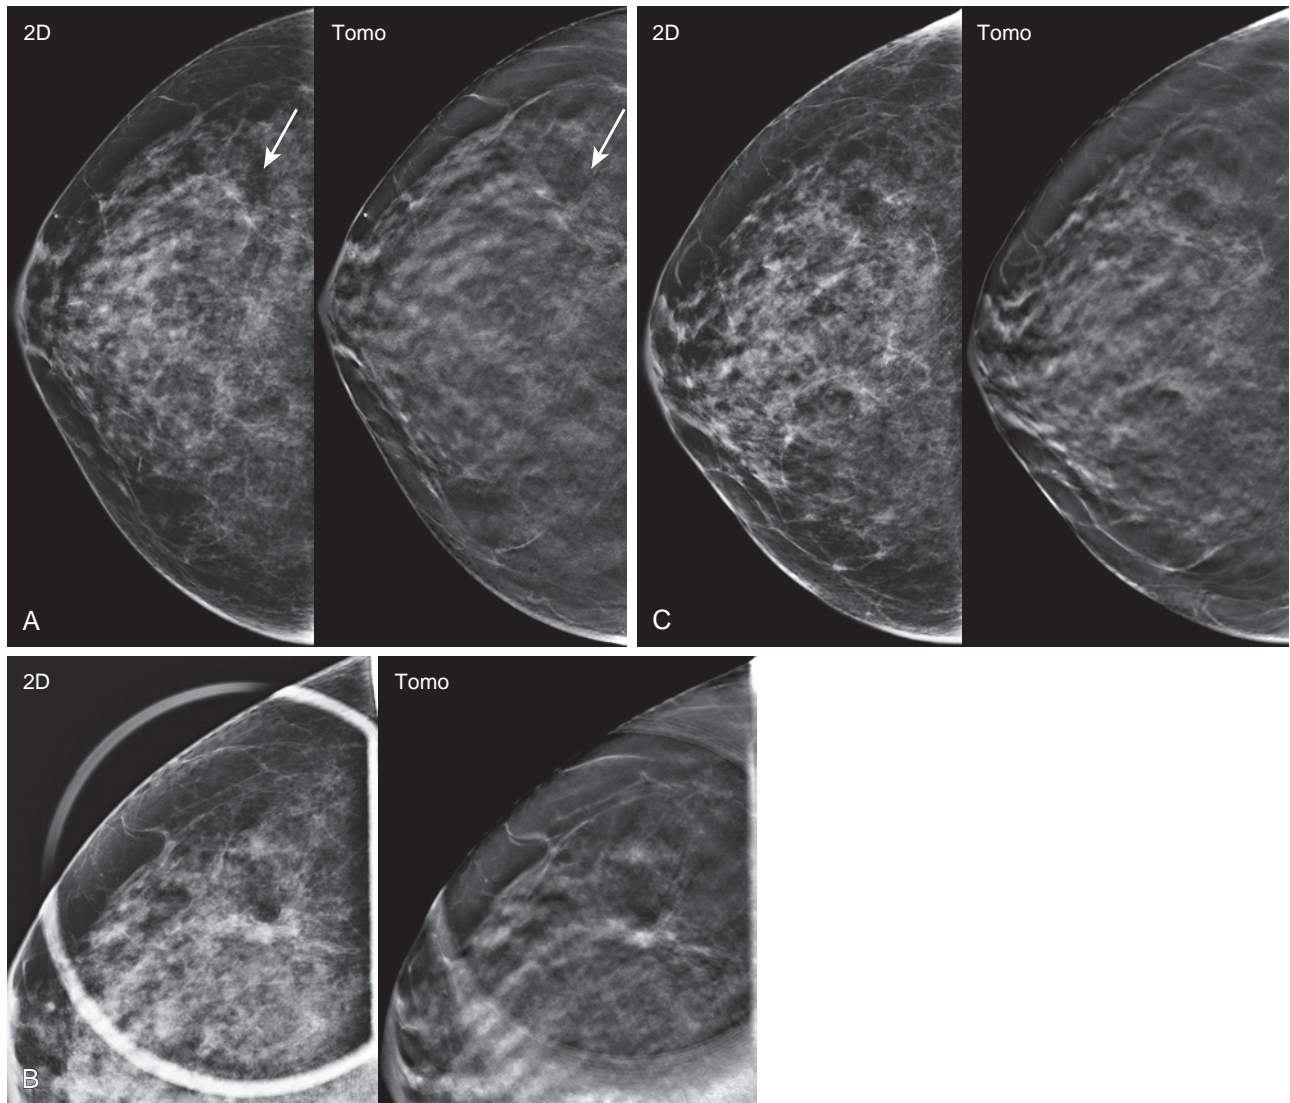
(A) A 63-year-old woman with a history of left breast cancer presents for annual diagnostic surveillance mammography. An area of architectural distortion (*arrows*) was detected in the lateral aspect of the right breast, seen on the craniocaudal view only. (B) This finding persisted on tomosynthesis spot compression views. Ultrasound revealed no abnormalities in the lateral aspect of the breast. Given the patient's history and the persistence of architectural distortion, magnetic resonance imaging was performed, which showed no suspicious findings. Breast Imaging Reporting and Data System (BI-RADS) 3, short-interval follow-up was recommended. (C) A 6-month follow-up right mammogram revealed the architectural distortion to no longer be reproduced. BI-RADS 2.
